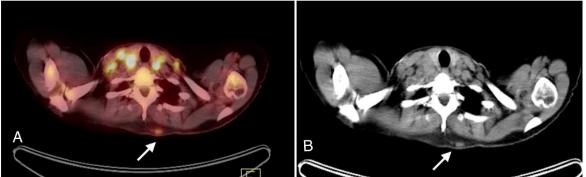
PET/CT fusion (A) and CT (B) images demonstrated a metabolically active subcutaneous lesion in upper posterior chest wall
